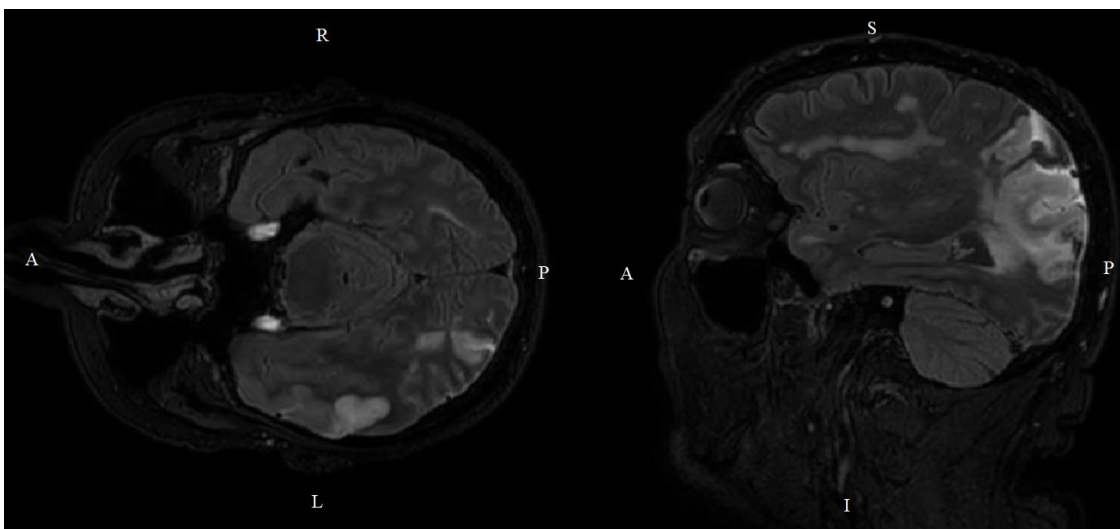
s_51's flair-MRI showing the left-sided temporo-parietal lesion
